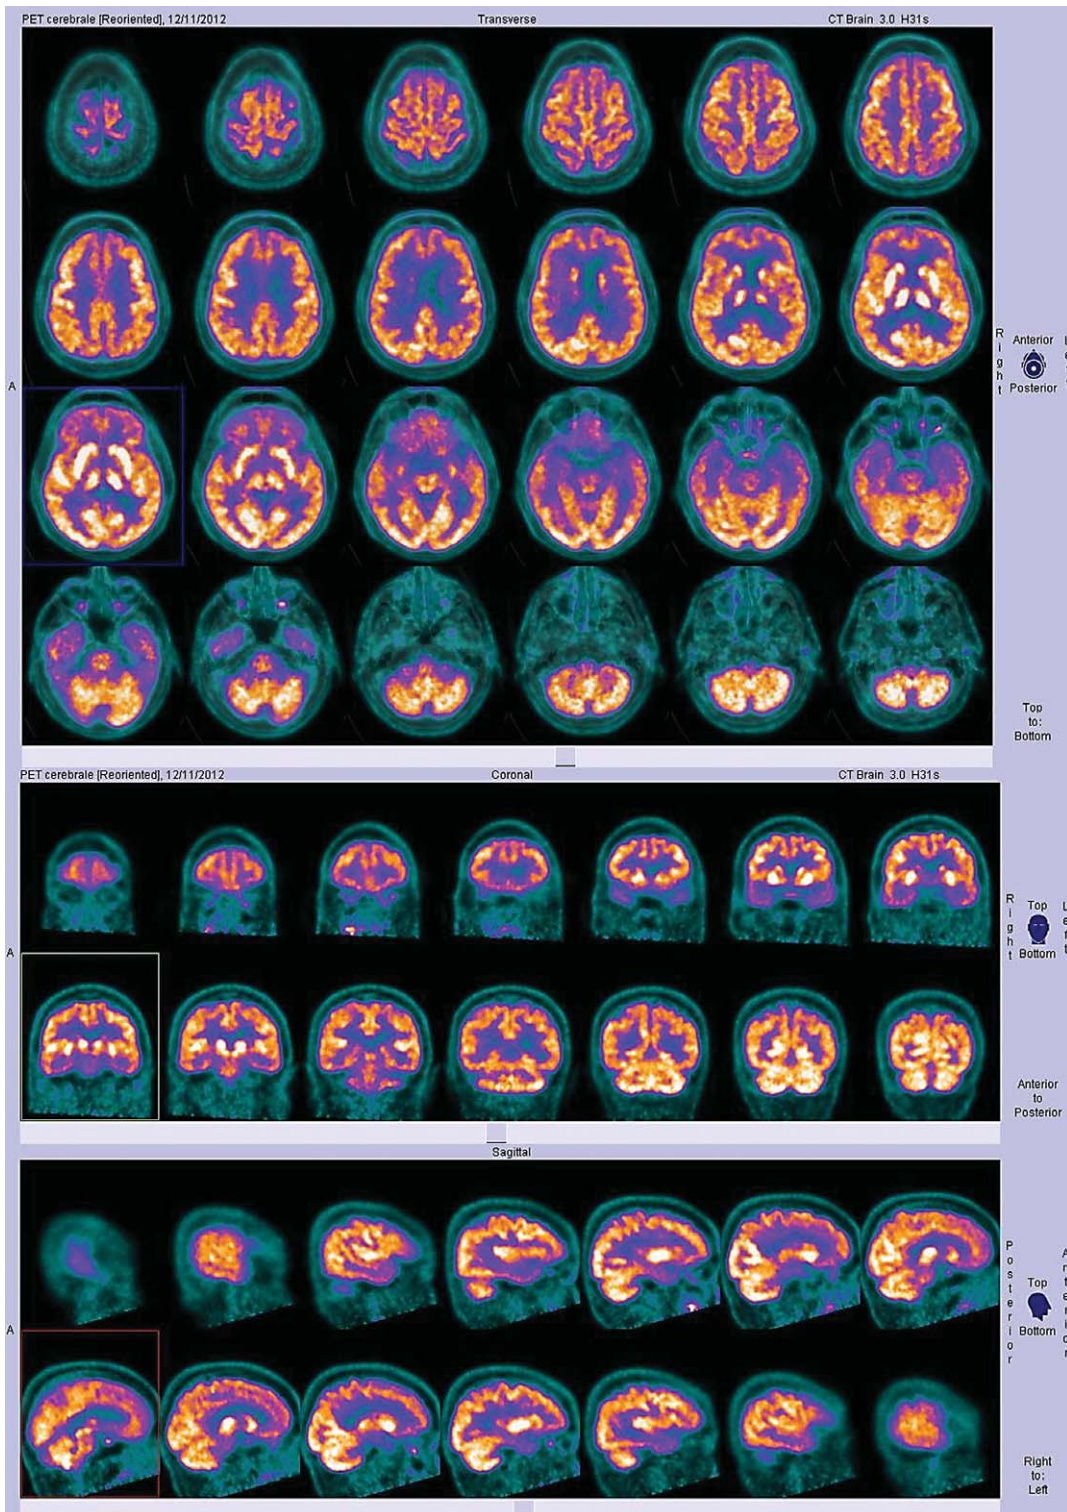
FDG-PET scan demonstrating diffuse cortical hypometabolism, more pronounced on bilateral basal frontal and temporal polar cortex.
